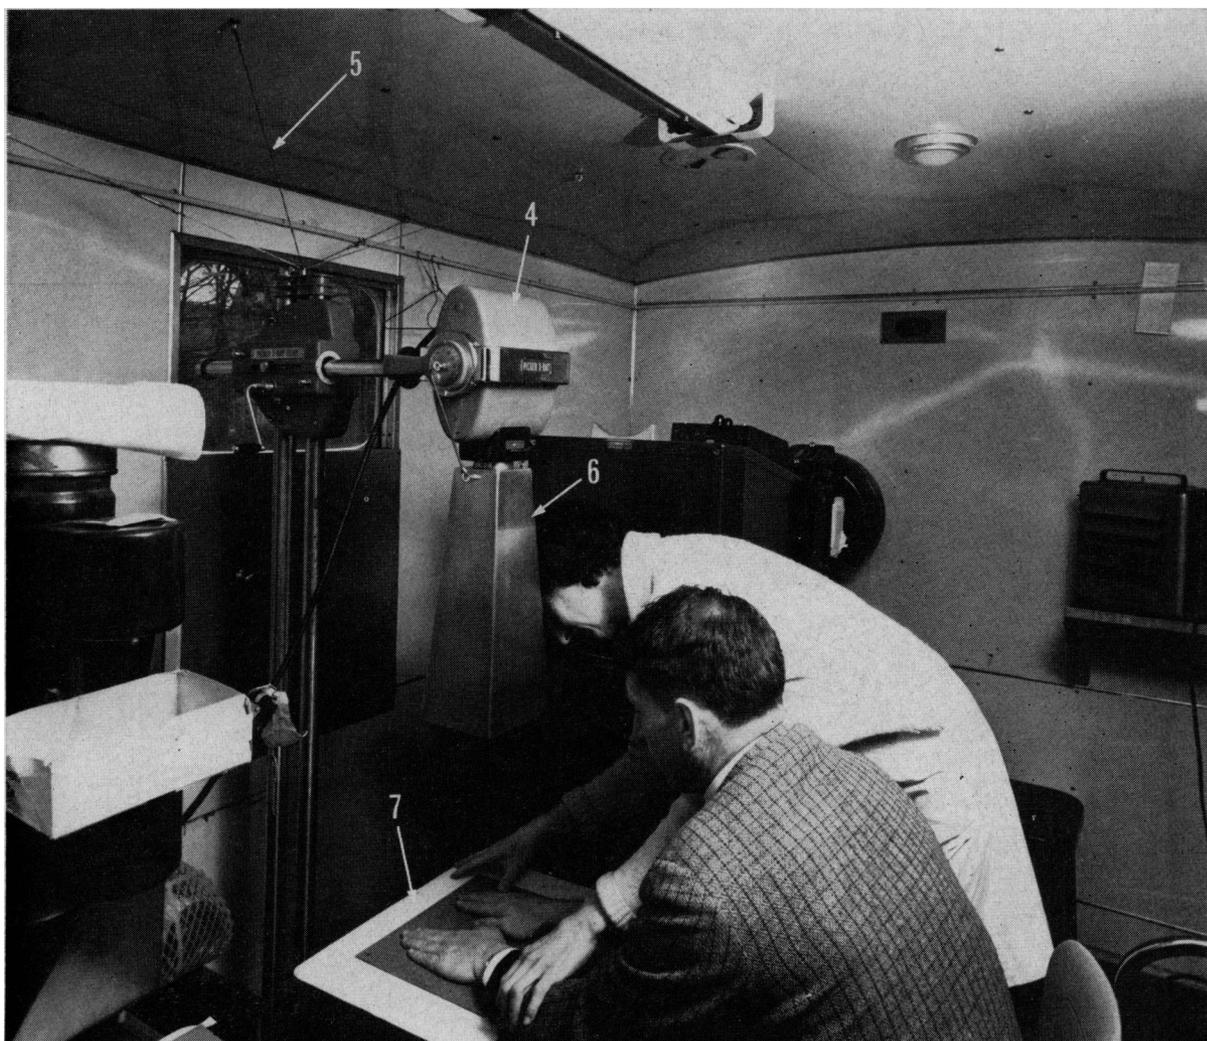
X-ray tube in position for radiographing hands. Wires securing column to ceiling (5), special cone (6), and tube at top of column (4)
